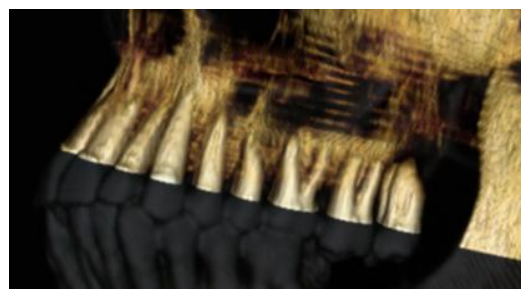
(b) upper left teeth roots of the antemortem mid-face CT with 80% opacity over upper left teeth roots of PMCT.
